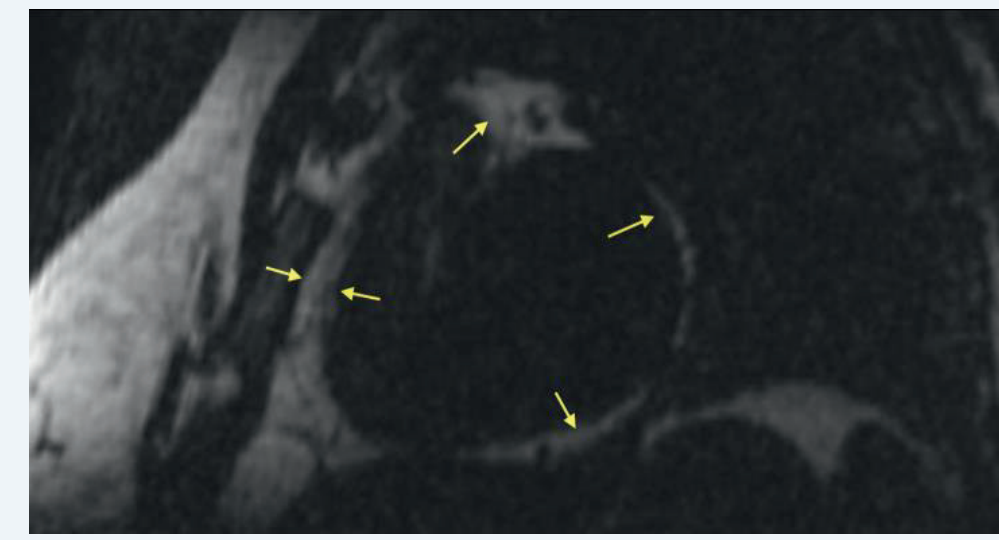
3D Dixon MRI Image in short axis view. Yellow arrows point at epicardial adipose tissue.
